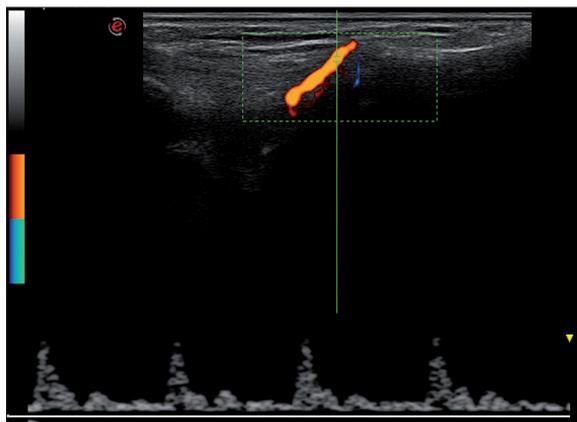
Spectral Doppler wave image obtained from normal blood vessel, high-resistance type. Dorsal close to sagittal US image at the level of carpo-metacarpal joint of the thumb.
